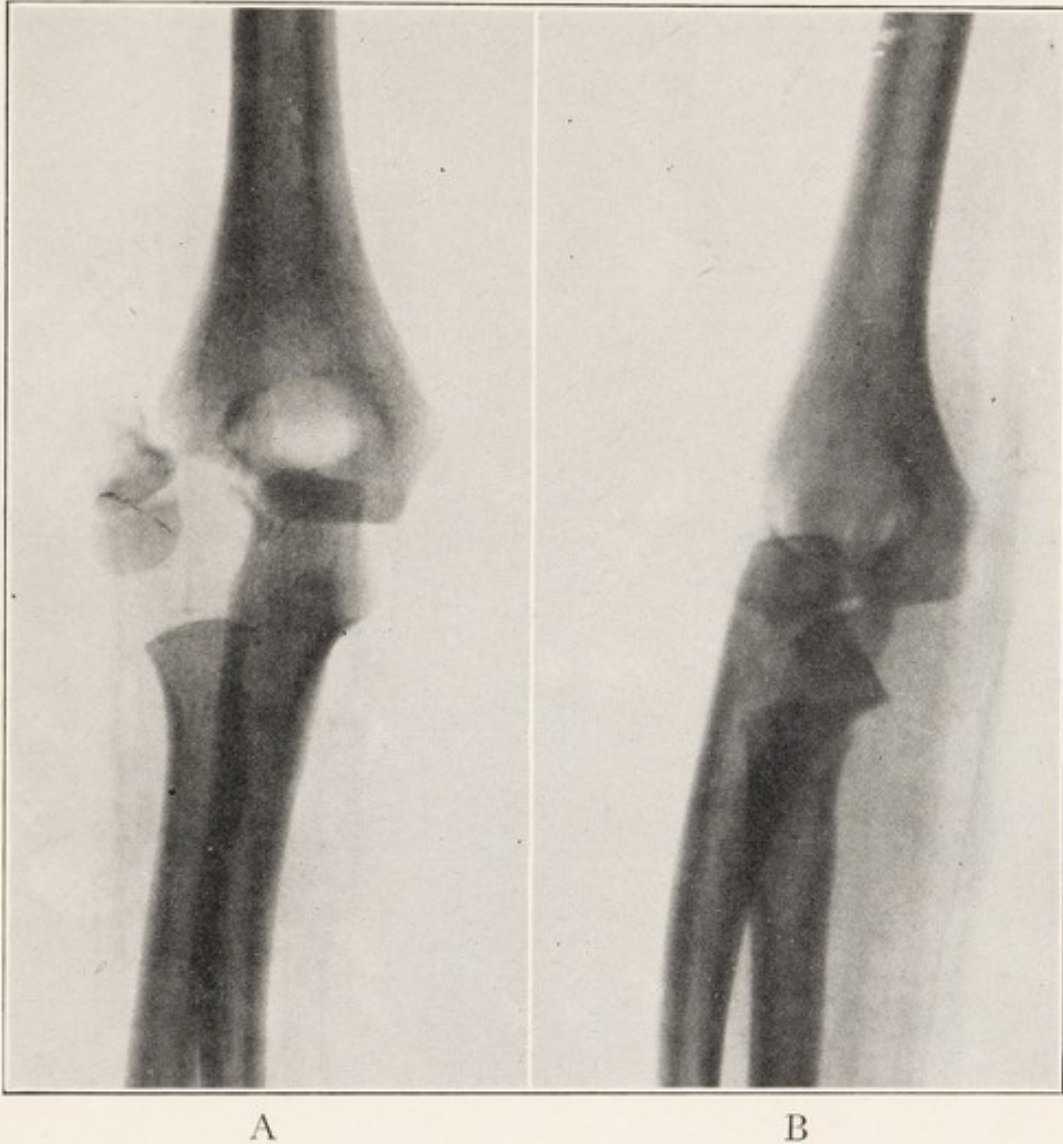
X-RAY SHOWING FRACTURE OF EXTERNAL CONDYLE OF HUMERUS WITH WIDE SEPARATION, ANTEROPOSTERIOR VIEW.
